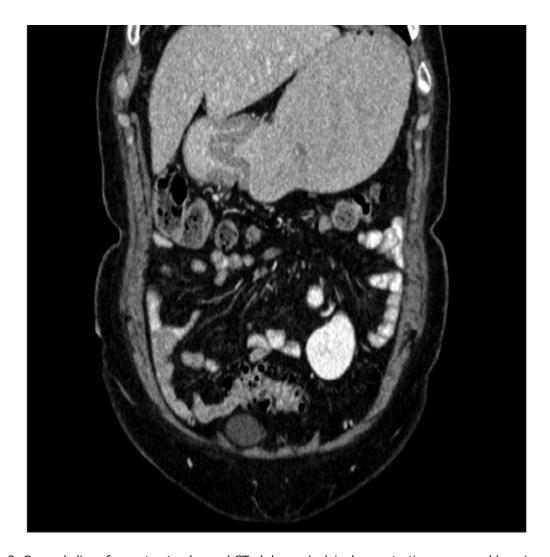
Coronal slice of a contrast enhanced CT abdomen/pelvis demonstrating a mucosal layering seen in GI intussusception. 107x109mm~(150~x~150~DPI)
